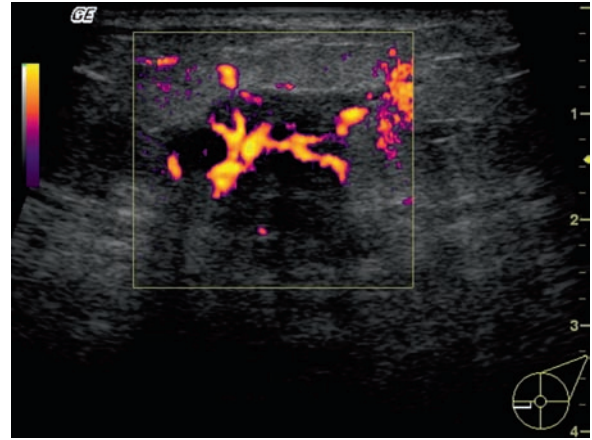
Ultrasound of a breast cancer demonstrating the vascularity of the cancer
